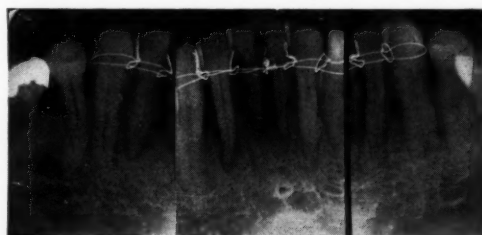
Roentgenogram showing splint in place. Teeth had been loosened by periodontal disease.
